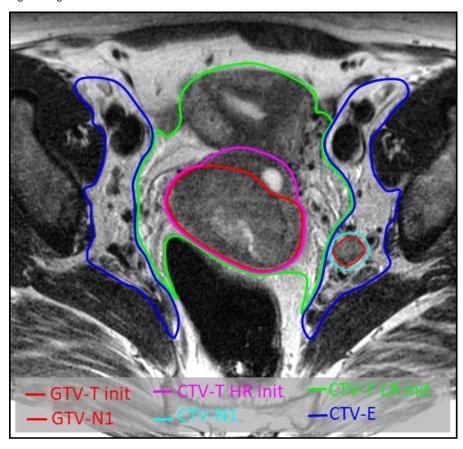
Summary of the delineation of GTVs and CTVs on a representative axial MRI slice.
